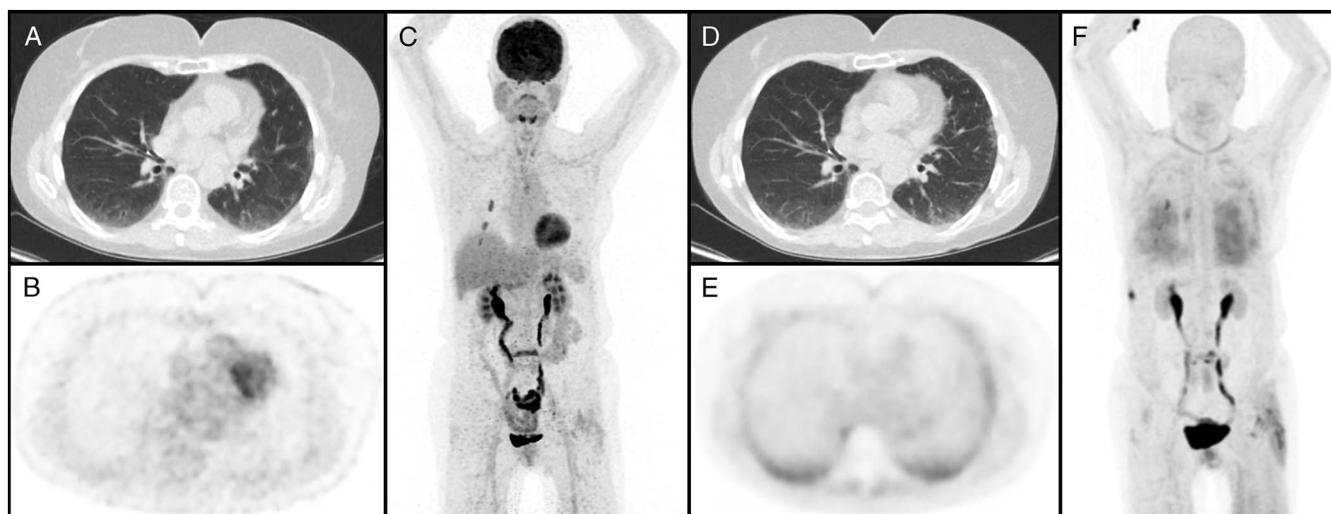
Comparison of ^{18}F -FDG PET/CT (A–C) and ^{68}Ga -FAPI-46 PET/CT (D–F): the corresponding transaxial low-dose CT scans (A and D) and PET emission scans (B and E), together with the coronal MIPs (C and F). Showing no relevant accumulation of FDG but an accumulation of FAPI-46, 19 weeks after discharge from hospital, in residual peripheral ground-glass opacities and subtle reticular changes shown in the corresponding low dose CT scans. In addition, a serial rib fractures rights and inflammatory changes in left hip were detected on both scans.
